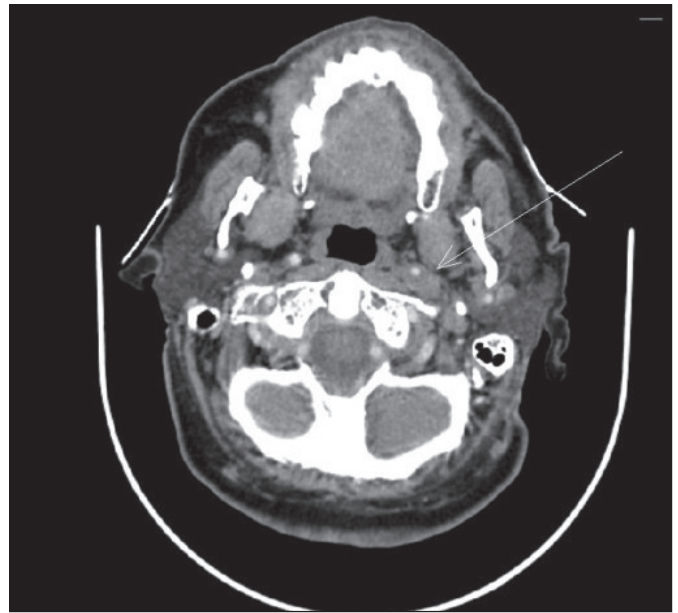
CTA, sequence of acquisition. Narrowing of the arterial lumen and intramural hematoma.
